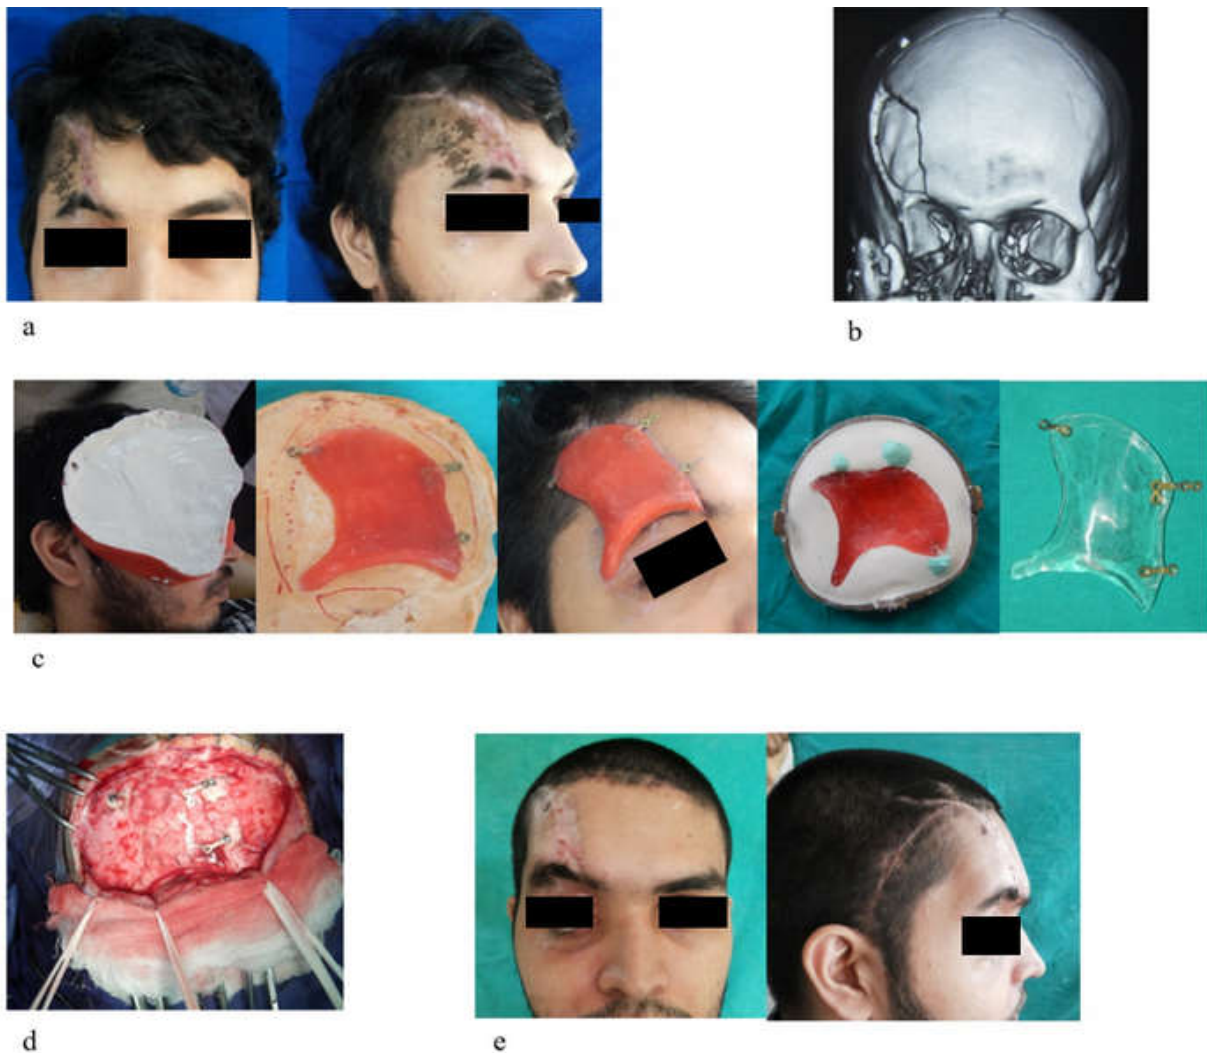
Case 4. a. pre-op photographs , b. pre-op CT, c. fabrication of prefabricated PMMA d. intra- op photographs, e. post-op photographs
